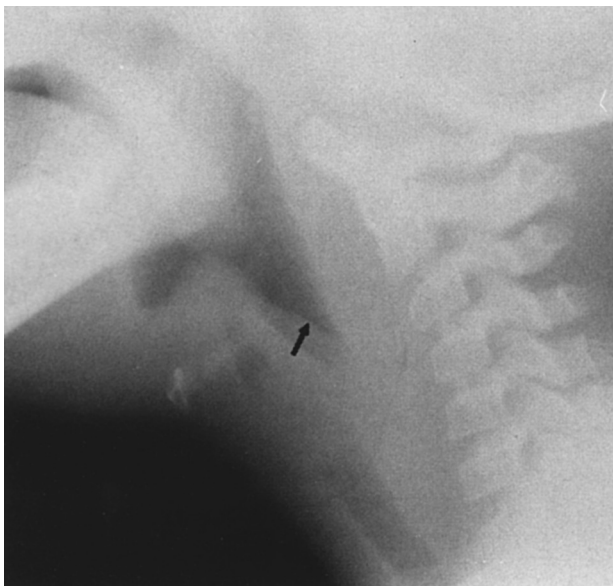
Epiglottitis. The patient is a 3 1/2 year old child with fever and sudden onset of stridor. Lateral radiograph shows an enlarged epiglottis ("thumb-print" sign) and aryepiglottic folds (arrow) and distention of the pharynx.
